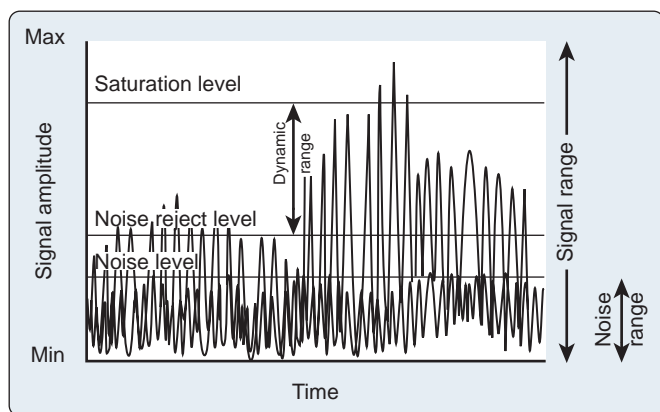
Dynamic range of a representative echocardiographic display system. All ultrasound signals begin at zero signal level and can increase in amplitude until they reach the signal saturation level. Many of the low-intensity signals fall within the range of the background noise and are therefore obscured. All systems have a built-in system reject, which eliminates both the system noise and the low-intensity echoes that lie just above the noise level. The dynamic range of the system is between the noise reject level and the saturation level. Signals within the dynamic range appear on the image display. (From Thys DM, Hillel Z. *How it works: basic concepts in echocardiography*. In: Bruijn NP, Clements F, eds. *Intraoperative Use of Echocardiography*. Philadelphia: JB Lippincott; 1991:255–318.)
